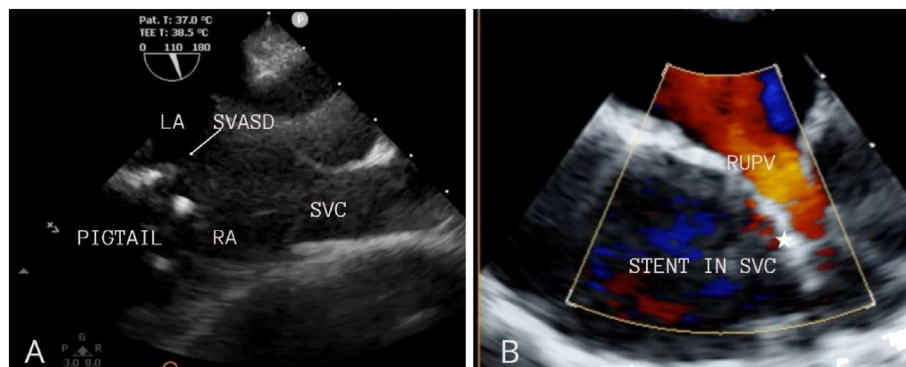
A. Transesophageal Echocardiogram Showing pigtail in the lower end of sinus venous atrial septal defect (SVASD). Successful deployment of stent creating partition (solid star) between SVC and Right upper pulmonary vein (RUPV) with unobstructed drainage of RUPV into Left atrium (3 B).
